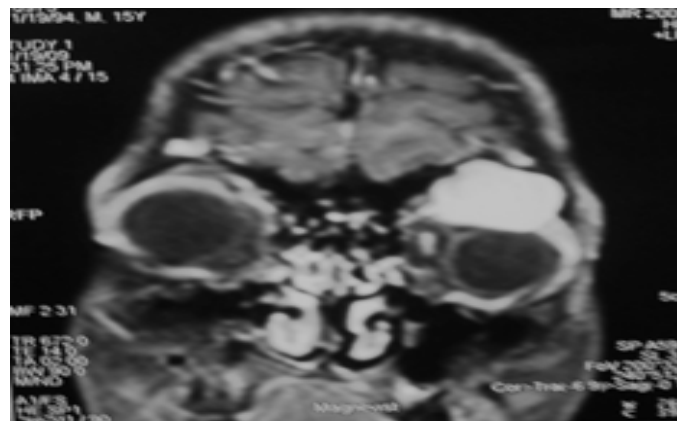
MRI : Contrast enhanced coronal view showing displacement of the globe.
